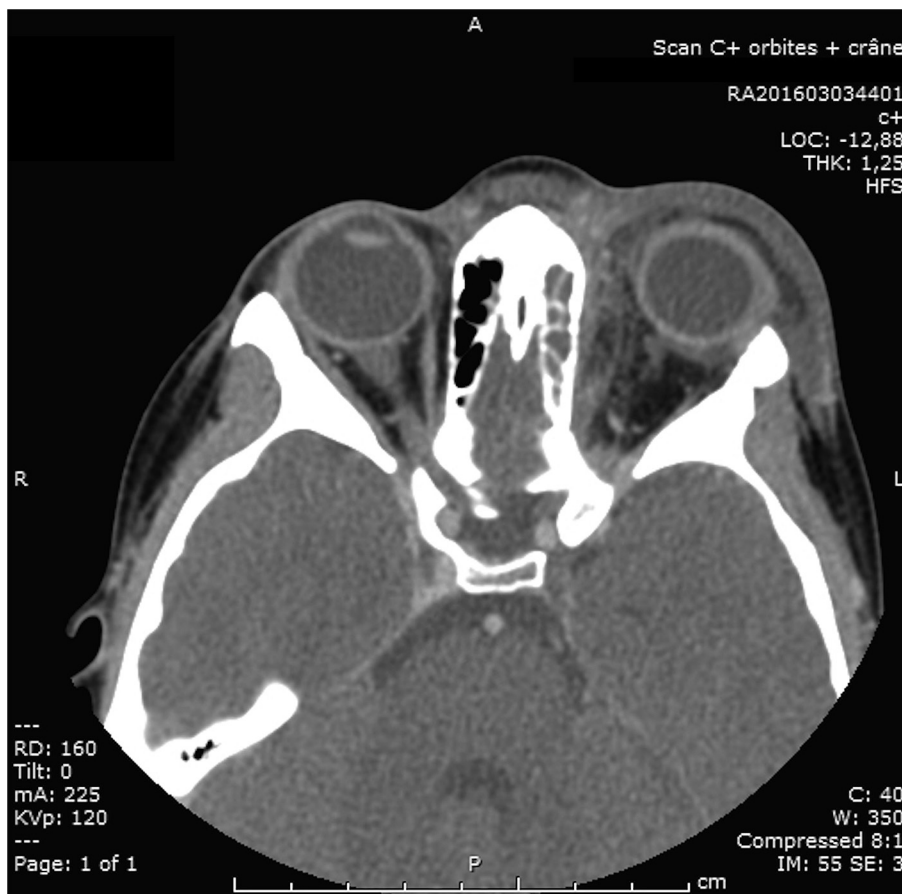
Patient 2 at presentation. Orbit computed tomography showing left ethmoidal sinusitis with a 5.7-mm-thick intraorbital phlegmon adjacent to the left lamina papyracea. In addition, the left proptosis and the orbital fat infiltration are all consistent with a left orbital cellulitis associated with a medial-wall phlegmon.
